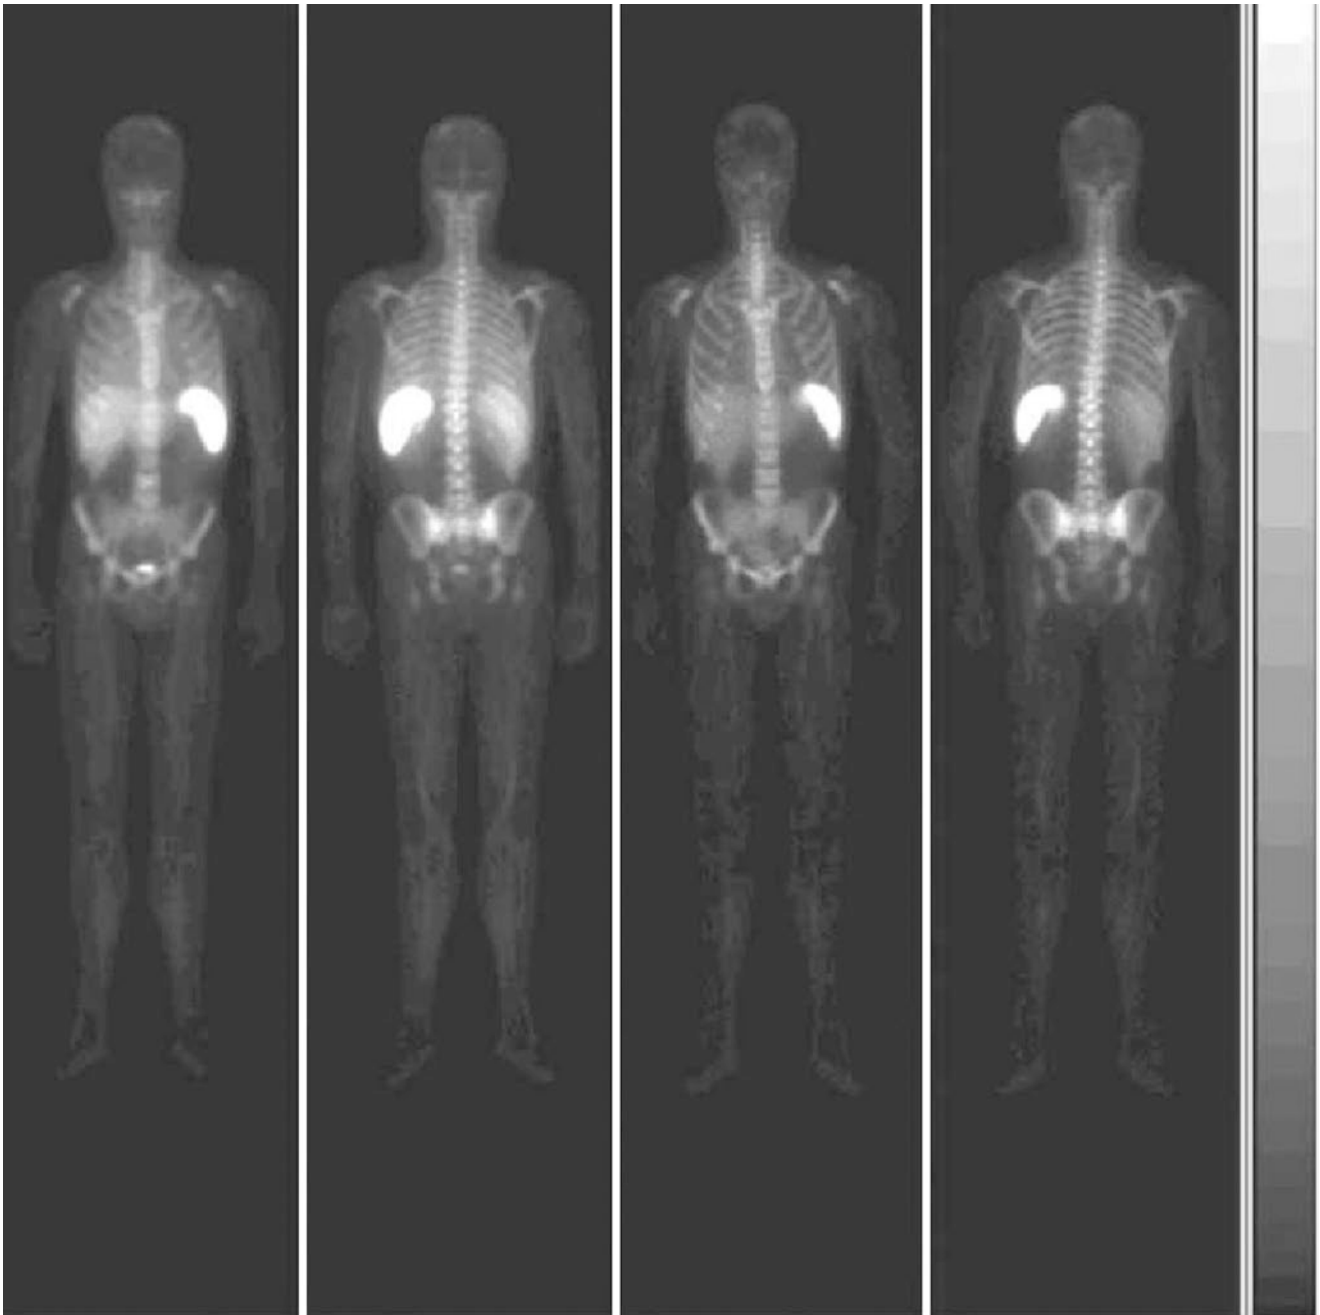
^{99m}Tc -HMPAO-leukocyte scintigraphy: anterior and posterior whole body images acquired 30 min p.i., showing physiologic uptake of labeled leukocytes in the spleen, liver, and bone marrow
